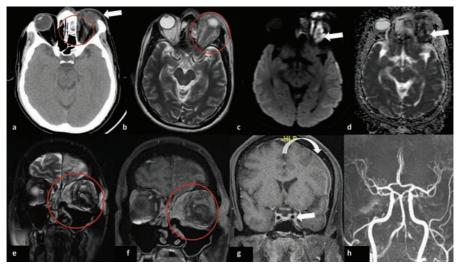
(a) Axial computed tomography of the orbit showing proptosis of the left eye with thickened preseptal soft tissue (white arrow). The adjoining ethmoid air cells show hyperattenuating mucosal thickening with inflamed intraorbital fat (red circle) adjacent to the lamina papyracea. (b) Axial T2 weighted imaging (T2WI) showing inflamed intra- and extraconal fat of the left orbit with proptosis and thickened preseptal soft tissue (red circle). Note the mucosal thickening of the left ethmoid air cells with relative hypointense signal (black arrow). (c, d) Diffusion-weighted imaging and apparent diffusion coefficient (ADC) maps showing restricted diffusion (white arrows) in the infective soft tissue pointing towards abscess formation. (e, f) Coronal T2WI fat-suppressed image (e) and coronal T1WI postcontrast (T1PC) (f) showing infective soft tissue extending from the left ethmoid air cells into the left orbit (red circles). (g) T1PC at the cavernous sinus level demonstrating normal appearance of sinuses (white arrow), thereby excluding cavernous sinus thrombosis. Note the pachymeningeal enhancement (curved arrow) along the cerebral convexity. (h) Time of flight (TOF) MR angiography showing normal morphology and course of the intracranial arteries.
